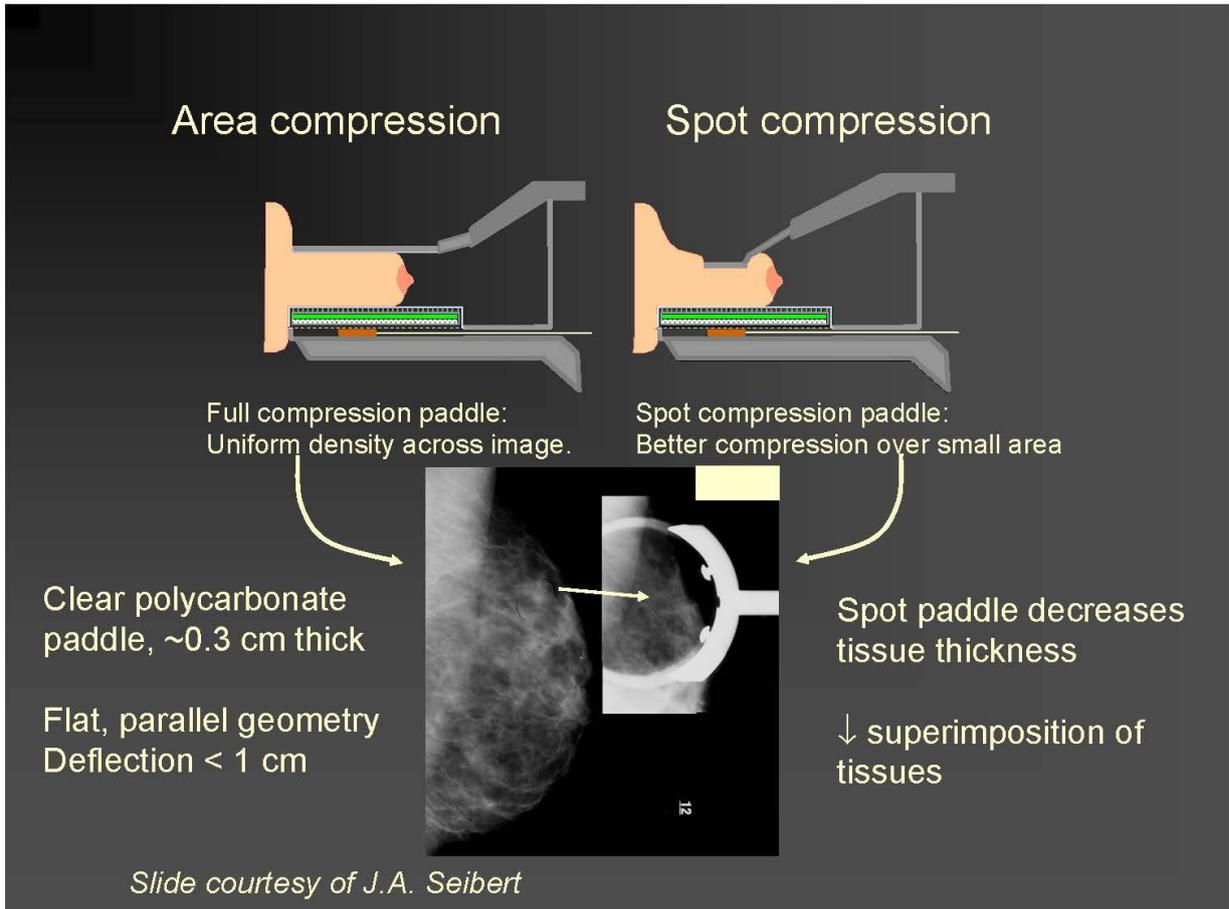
Images from: Medical Radiography and Photography, Kodak 62:2 1986
